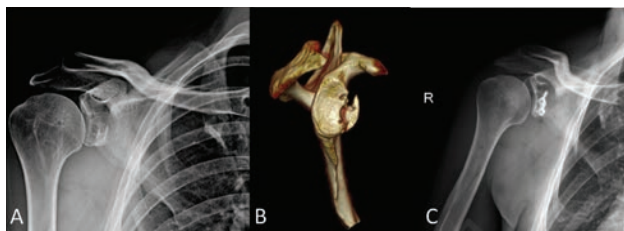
32-year-male patient. Arthroscopic anterior shoulder stabilization, ski accident and right shoulder fracture dislocation 3 years before; AP Radiograph (A) and 3D computerized tomography, with digitally subtraction of the humerus (B) of the anterior glenoid rim fracture of a trauma patient. (C) Early postoperative radiograph of the patient who underwent an open reduction and plate fixation using a "Latarjet plate" as a buttress plate, to avoid the displacement of the large fragment.
